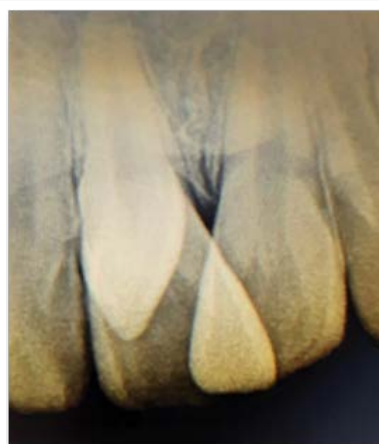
Radiographic examination, IOPA irt 11, 21
